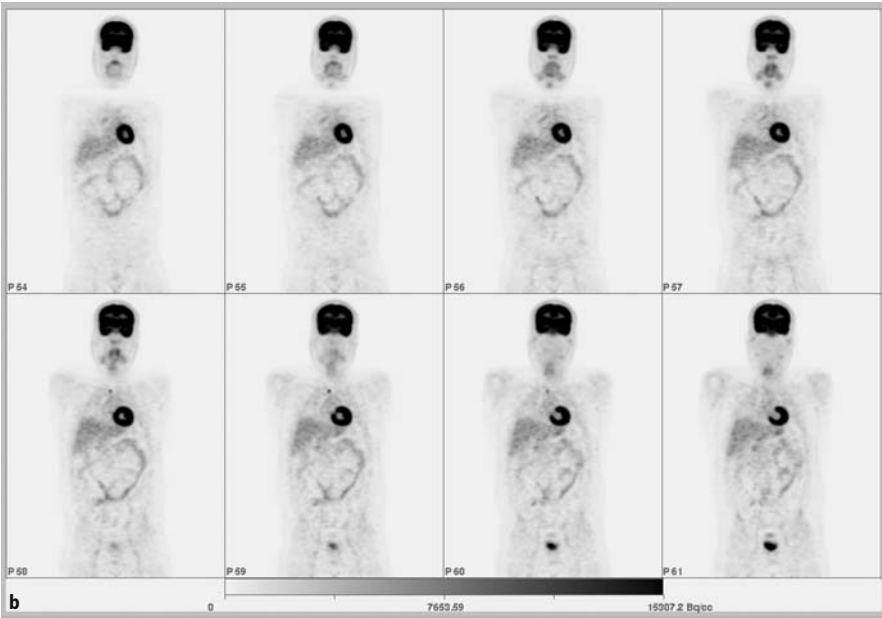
A 30-year-old male patient with papillary thyroid cancer presenting with elevated thyroglobulin values during follow-up. Radioiodine scan (a) is completely negative, whereas FDG-PET (b) shows a small lymph node metastases behind the right sternoclavicular joint
